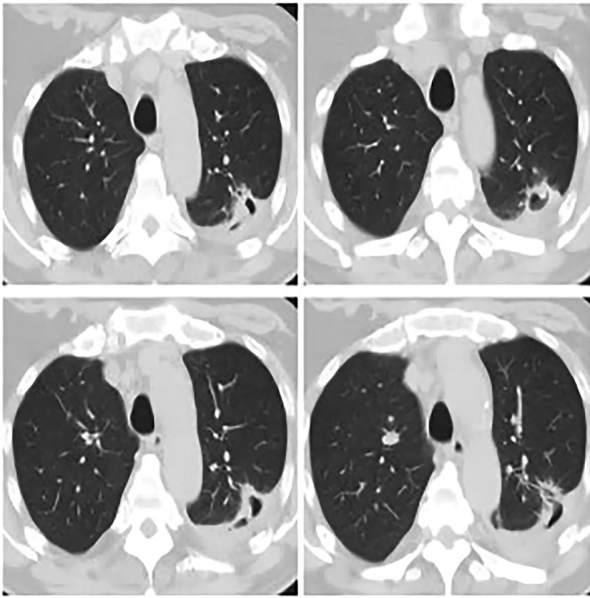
Chest computed tomography on the 35th day after admission showing a bronchial abscess with bronchopleural fistula in the left upper lung, a very difficult condition to treat without surgery.
